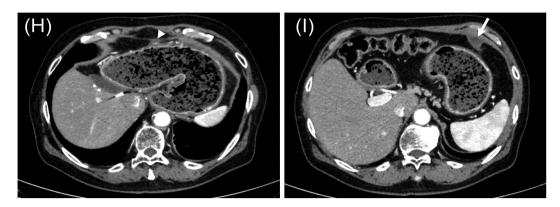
Changes in serum CEA and CA19-9 levels (A) and contrast-enhanced computed tomography images. Two peritoneal tumors were identified, one at the gastric wall (white arrowhead) and one at the abdominal wall (white arrow) (B and C). Images before starting pembrolizumab treatment (D and E). Images at the end of three courses of pembrolizumab (F and G). Images at the end of 18 courses of pembrolizumab (H and I).
